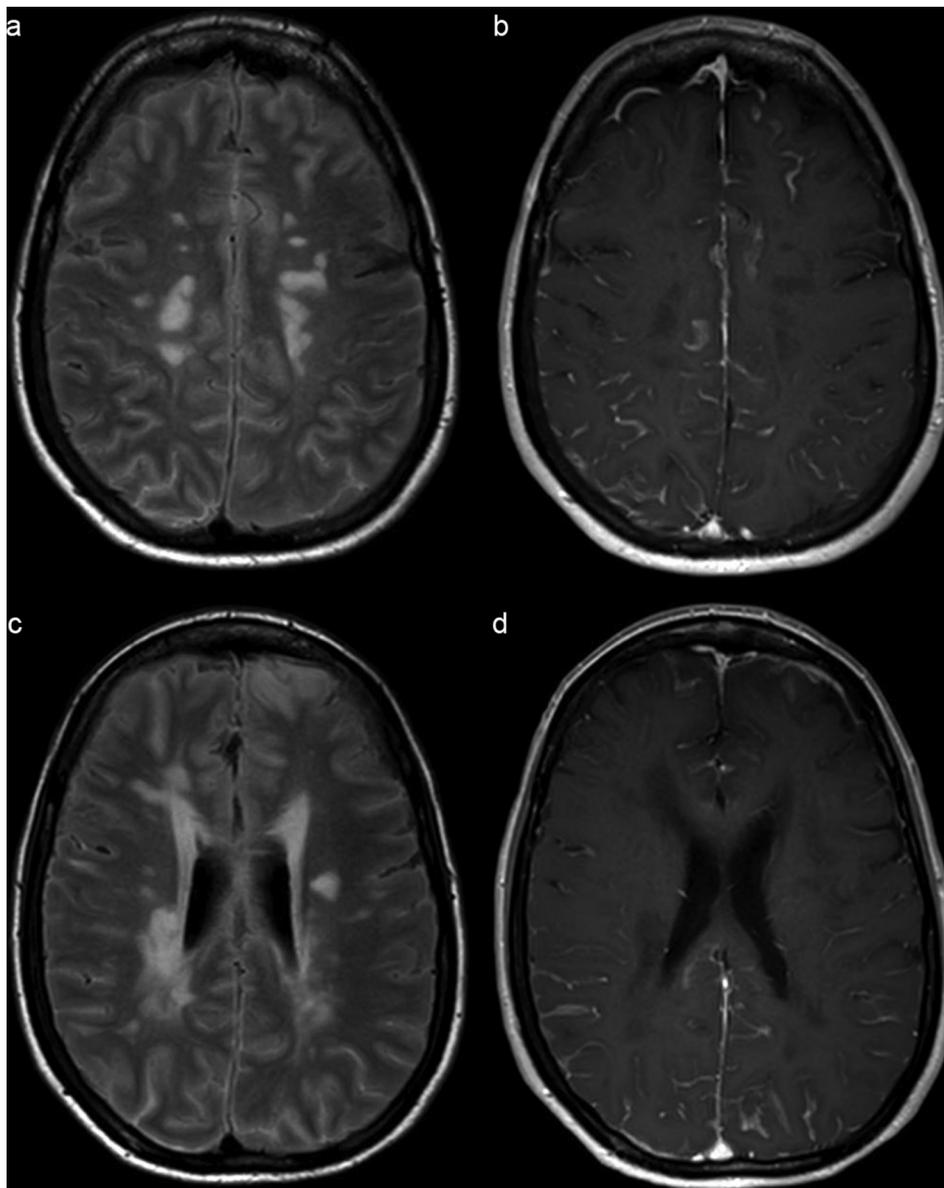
Axial T2-weighted FLAIR and T1-weighted post-contrast images at the level of the centrum semiovale (a, b) and the corona radiata (c, d) on a second follow up brain MRI performed one month after the prior demonstrate worsening leptomeningeal enhancement and the development of increased T2/FLAIR within the sulci.
